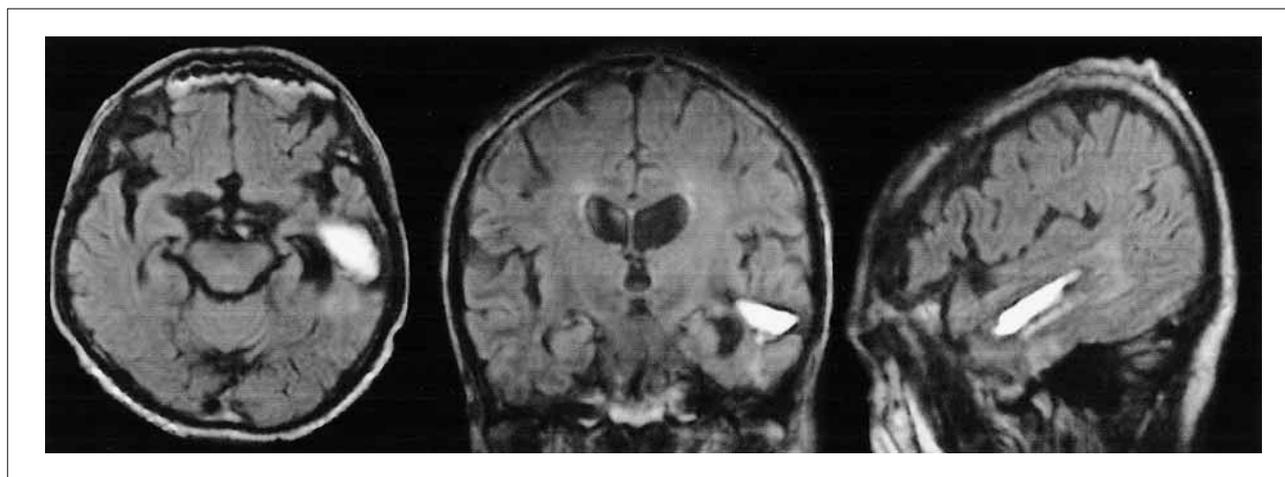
Fluid-attenuated inversion recovery (FLAIR) MR images taken two months after injury (left: axial; middle: coronal; right: sagittal section) demonstrated a hyperintensity area in the left middle temporal gyrus.
